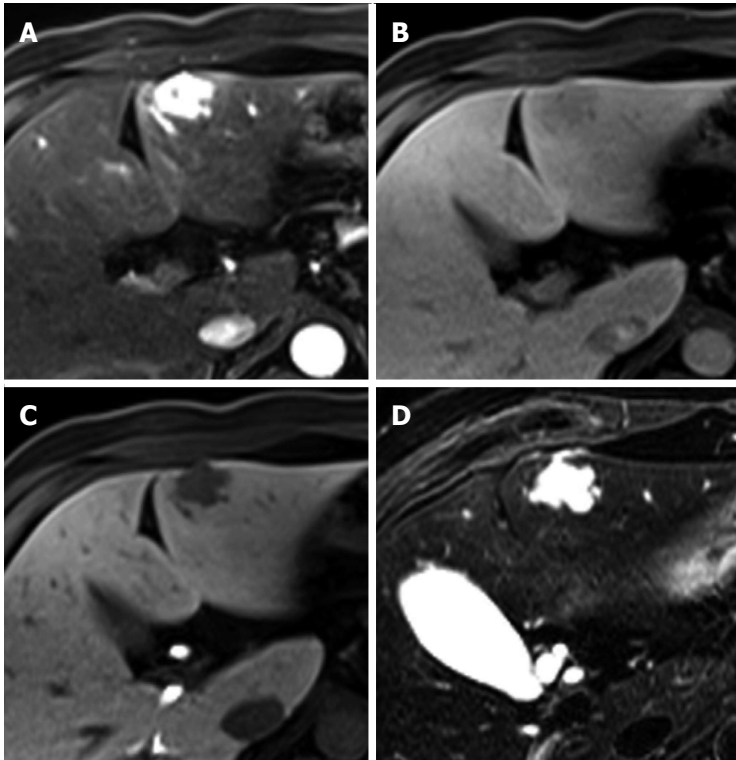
Hepatic hemangioma in a 54-year-old man. A: Hepatic arterial phase in gadoteric acid-enhanced MRI shows homogeneous marked enhancement of the tumor in segment 3; B: Transitional phase shows slightly low signal intensity of the tumor relative to the liver parenchyma; C: Hepatobiliary phase shows more markedly low signal intensity of the tumor; D: T2-weighted image shows bright and high signal intensity of the tumor.
